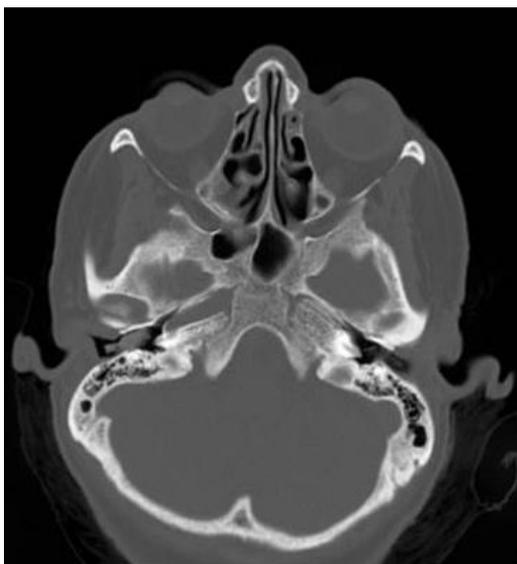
Absence of the left internal carotid canal on non-contrast head CT in the bone window
